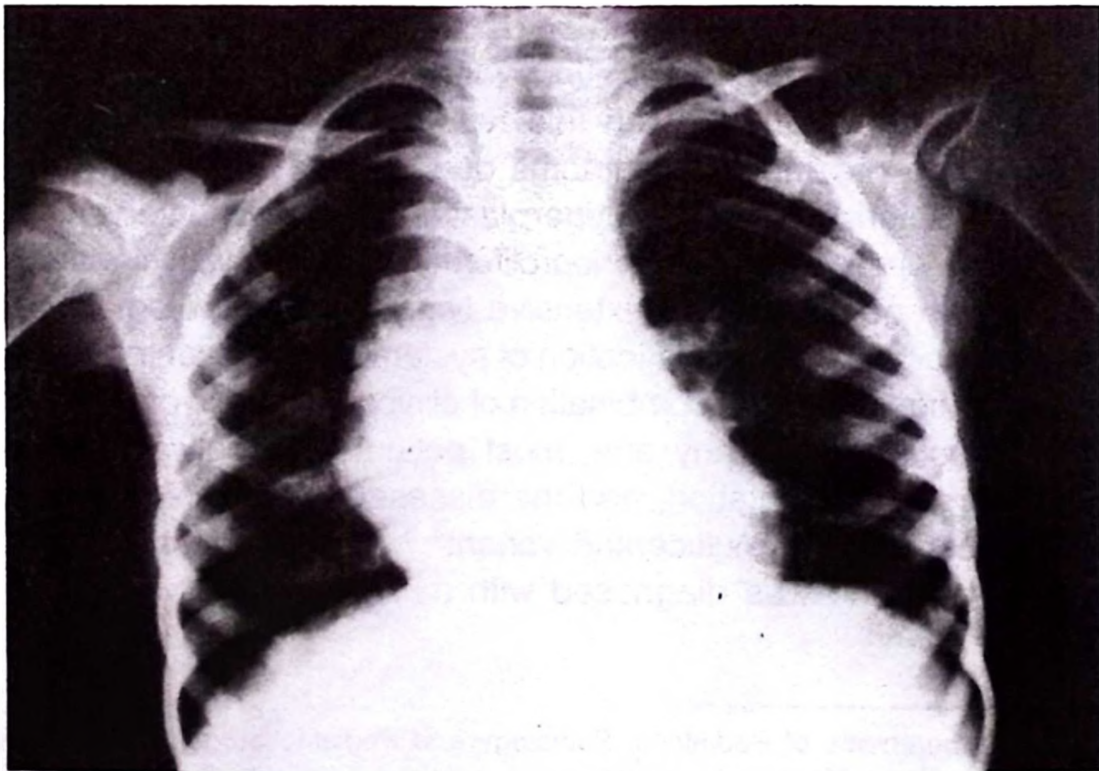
Postero-anterior chest x-ray showing mediastinal enlargement.
